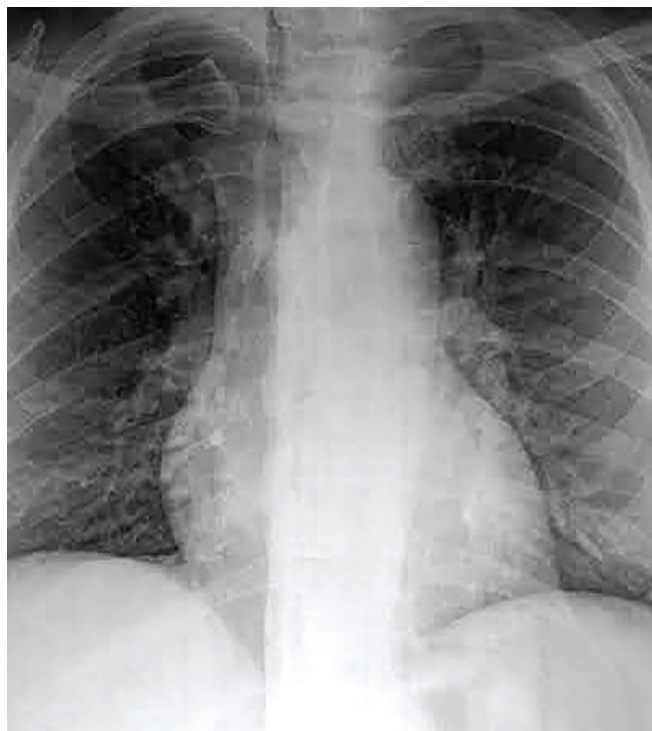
X-ray chest PA view was normal without any cardiomegaly or apical bulge.
